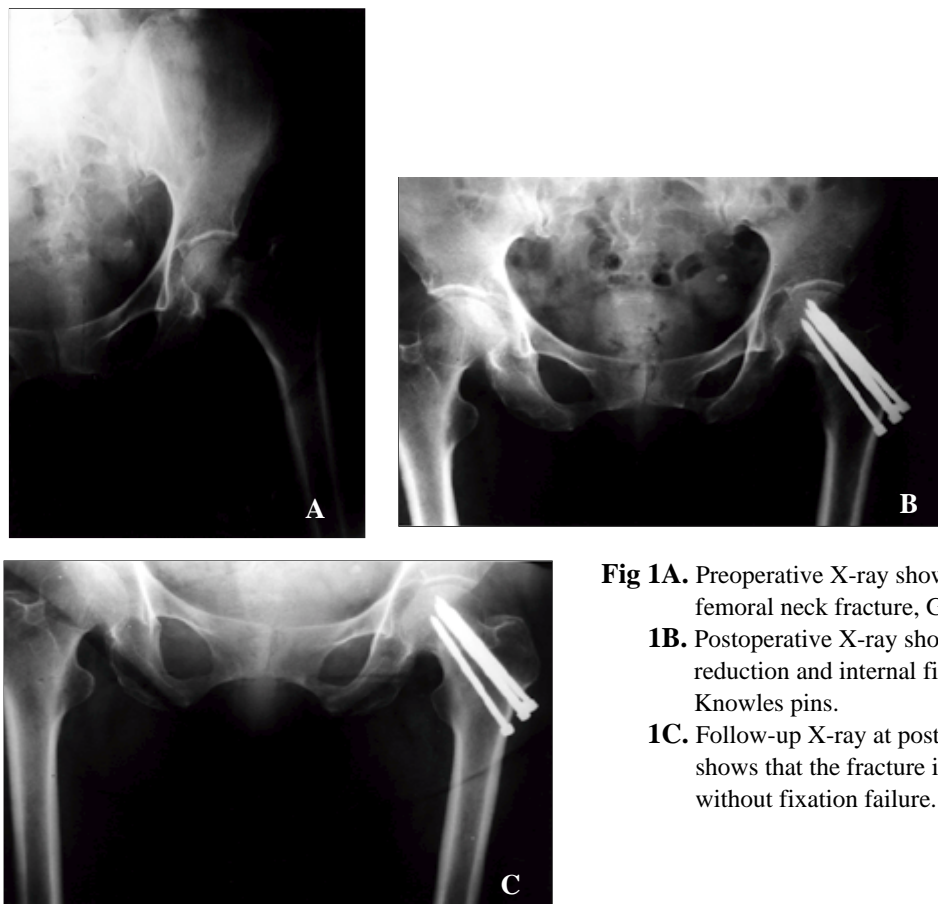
Preoperative X-ray shows subcapital femoral neck fracture, Garden 's type .
